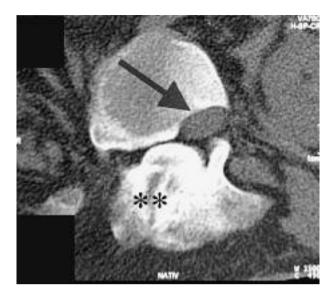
Axial computed tomography T12: spinal cord (arrow); facet joint hypertrophy ().
